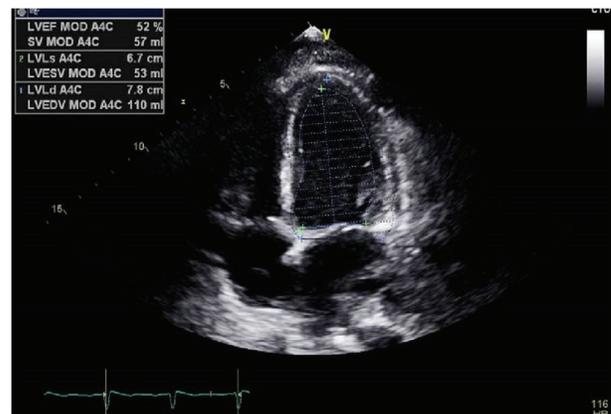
Echocardiogram showing normal left ventricular ejection fraction (LVEF).
